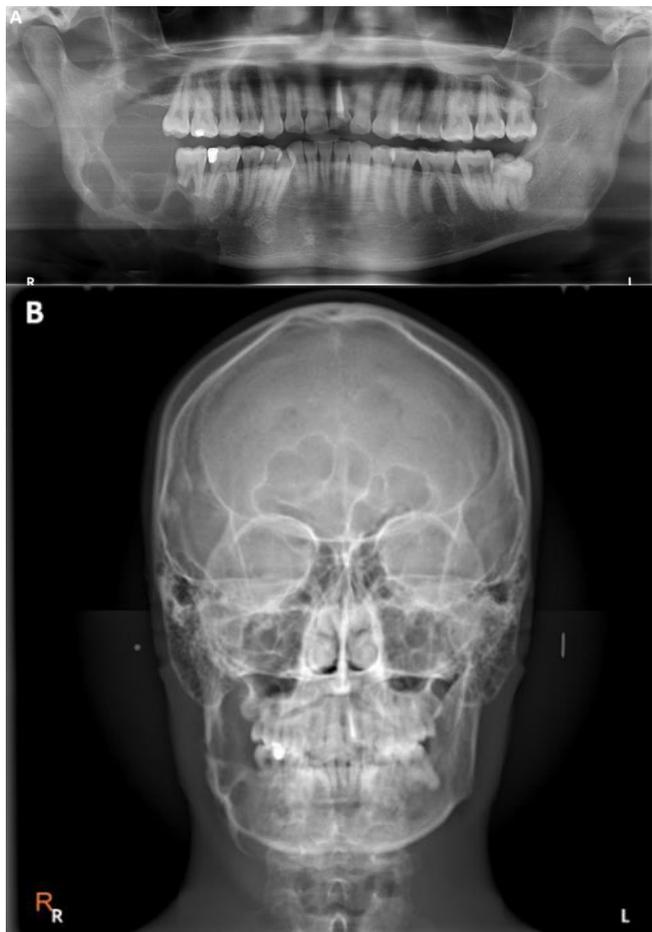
Pre-operative radiographs (A) Panoramic radiograph showed multilocular radiolucency at right posterior mandible involve inferior border of mandible. (B) Postero-anterior skull radiograph showed multilocular radiolucency with buccal expansion of right posterior mandible.
